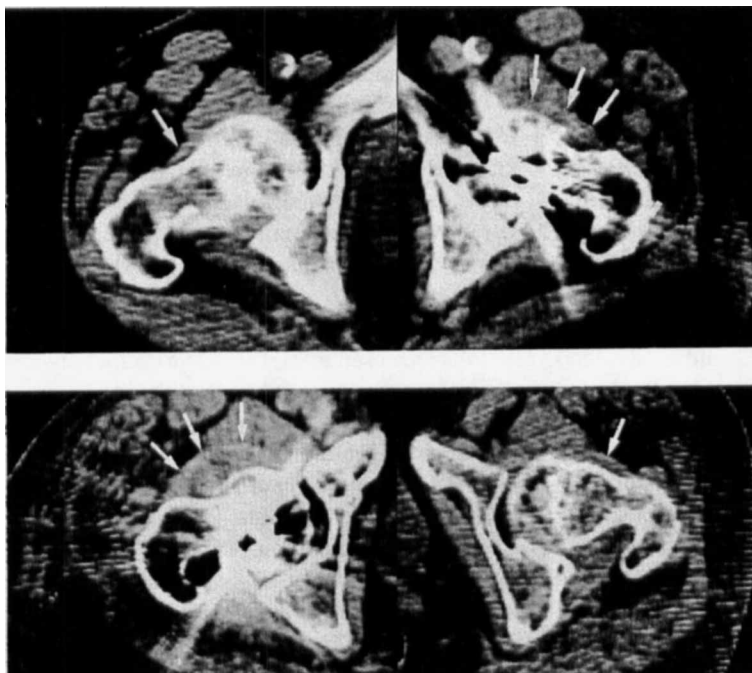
CT of the hips of a 79-year-old female with a left cervical hip fracture (Case 15 in Table 3). On the right normal side, the capsule (arrow) follows the neck equidistantly at 4.5 mm. The distance between the neck and the ventral aspect of the capsule on the left side is (arrows) 10 mm, indicating an effusion or capsular "thickening" of 5.6 mm. It is not possible to evaluate the posterior aspect of the capsule due to the transmission artefacts produced by the two metal pins.
